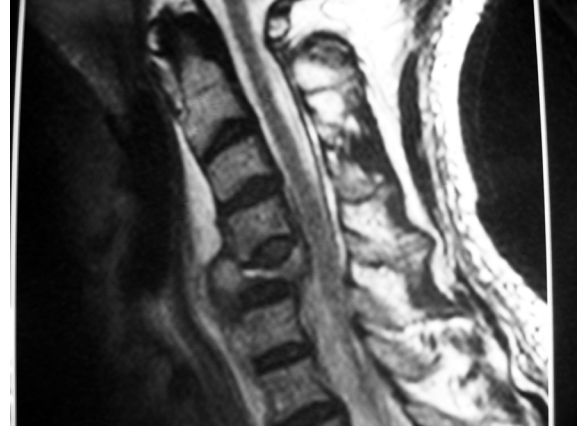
TSE T2-weighted sagittal MR image shows compression fracture at the 5th vertebrae corpus. Compressed vertebral body dislocated posteriorly. Anterior epidural space narrowed significantly.
